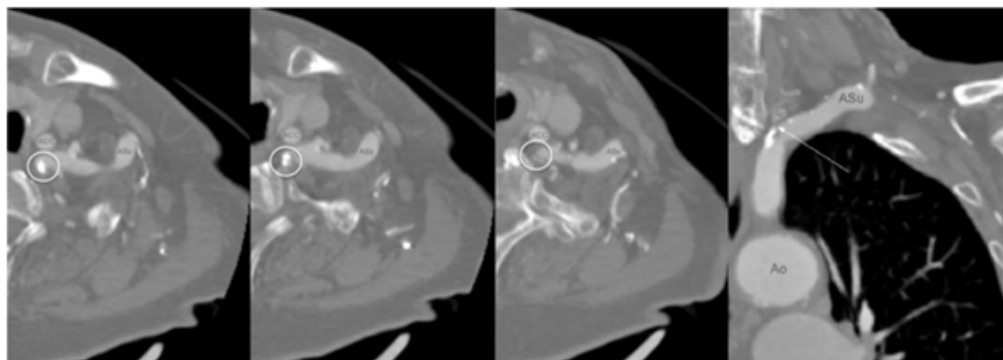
CTA: 3 axial reconstructions are arranged from bottom to top with a 1 mm difference and with an oblique adjustment in multiplanar reconstruction to demonstrate mixed atherosclerotic changes in the distal part of the left vertebral artery - circles and coronary reconstruction with oblique adjustment in multiplanar reconstruction, showing extensive atherosclerotic changes in the left vertebral artery with severe ostial stenosis of the - arrow (source: P.M.).
